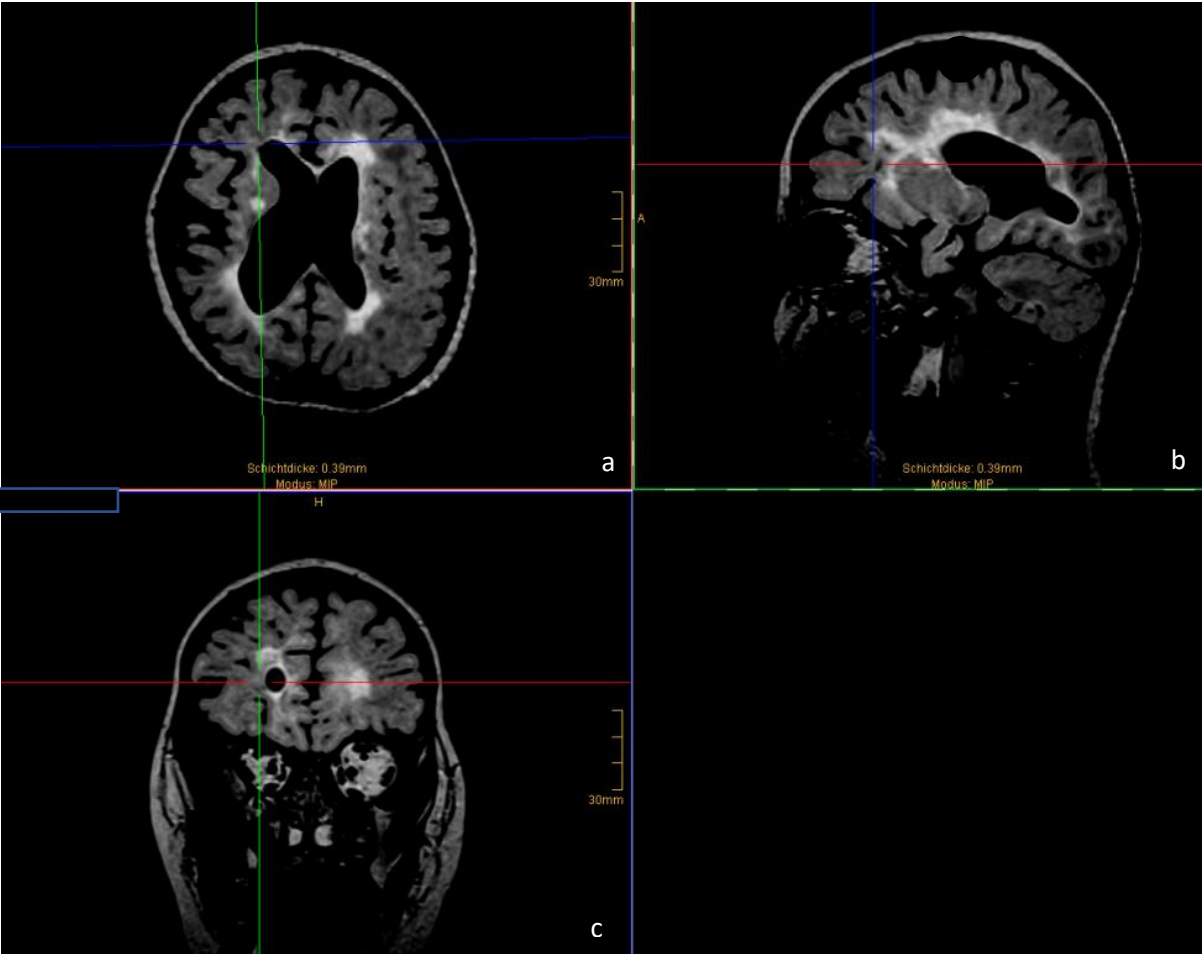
MRI showing reduced corticomedullar differentiation, Pat. 2, at age one year and ten months. Flair space, coronal sequence, 1mm, a: transversal, b: sagittal and c: coronal section. See pointer in the region anterior to the right frontal ventricle horn (area corresponding to bleeding in Figure 13).
